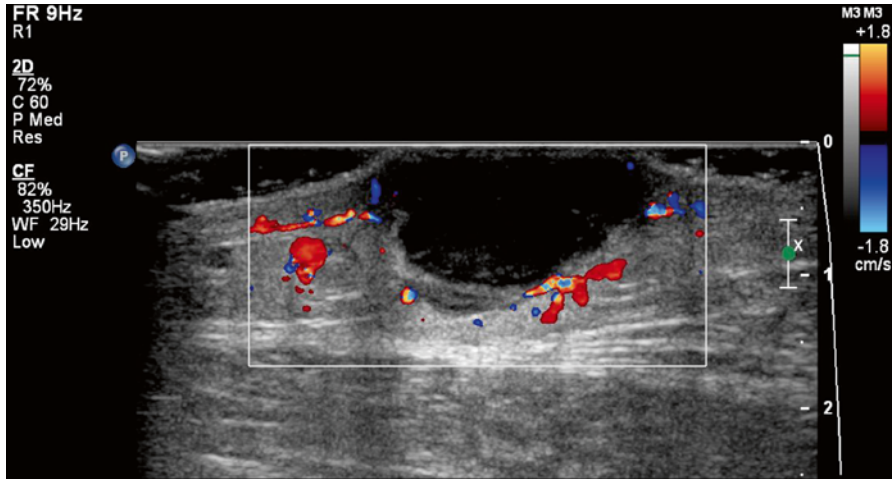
Ultrasound image of a patient post surgery shows an anechoic fluid collection that contains isoechoic debris just beneath the anterior abdominal wall in the right lower quadrant with adjacent hyperemia consistent with an abscess
